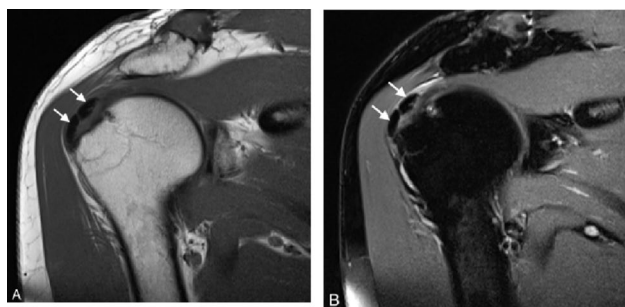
Right shoulder MR of a 45-year-old male patient with painful RCCT, images show a calcification appearing as focal area of low signal on all sequences (arrows) within the supraspinatus tendon. A Coronal T1-weighted. B Fat-suppressed proton density weighted
